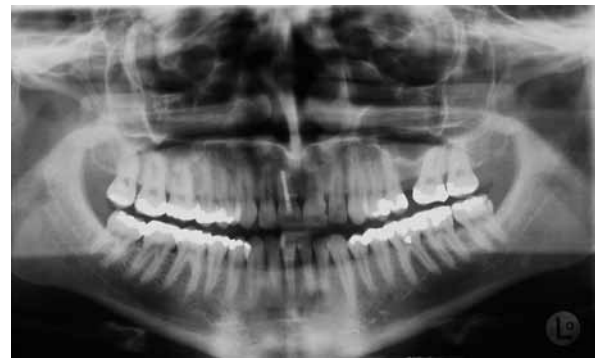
Orthopantomographic image before the start of orthodontic treatment. An apical lucency at tooth 31. Pronounced maxillary-antrum expansion between teeth 25 and 27. Orthodontic closure of the gap is difficult.
